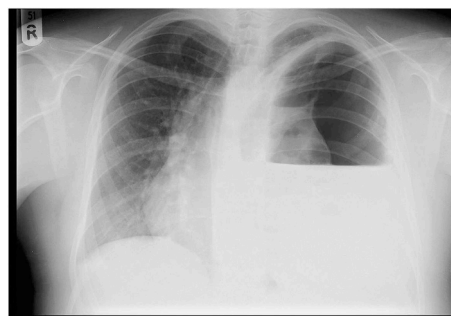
Erect chest radiograph on day of admission showing left tension hydropneumothorax with significant mediastinal displacement.
